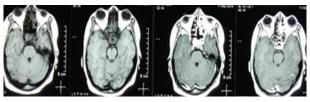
Post-operative MRI axial (T1 & T1 with contrast) showing evacuated complete abscess.
